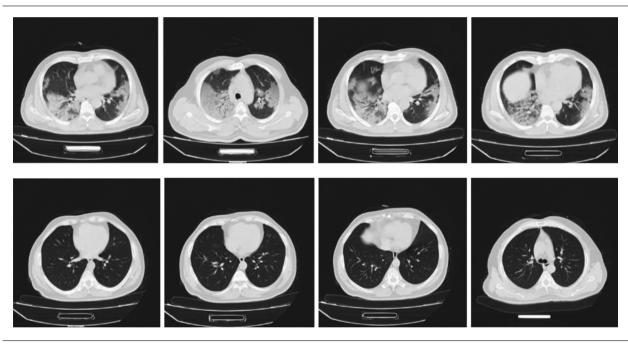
Computed tomography scan of case 3: A, In the first; and B, last days of the treatment
